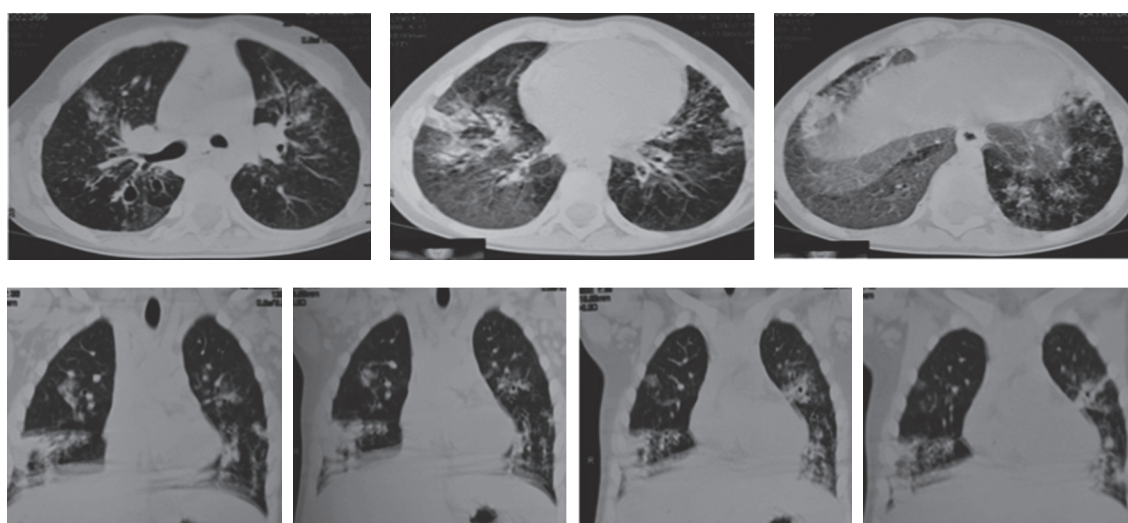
A 5-year-old female patient. A. HRCT image shows cystic and traction bronchiectasis, peribronchial cuffing, branching nodules and ground glass appearances are seen in the bilateral upper lobes predominantly in the anterior segments. Similar lesions are seen in the posterior basal segment of bilateral lower lobes. Multiple small nodules with subtle peripheral halo are seen in bilateral upper lobes. Intra and interlobular septal thickening with ground glass appearance is seen predominant in lateral basal segments bilaterally. No significant lymphadenopathy is seen.
